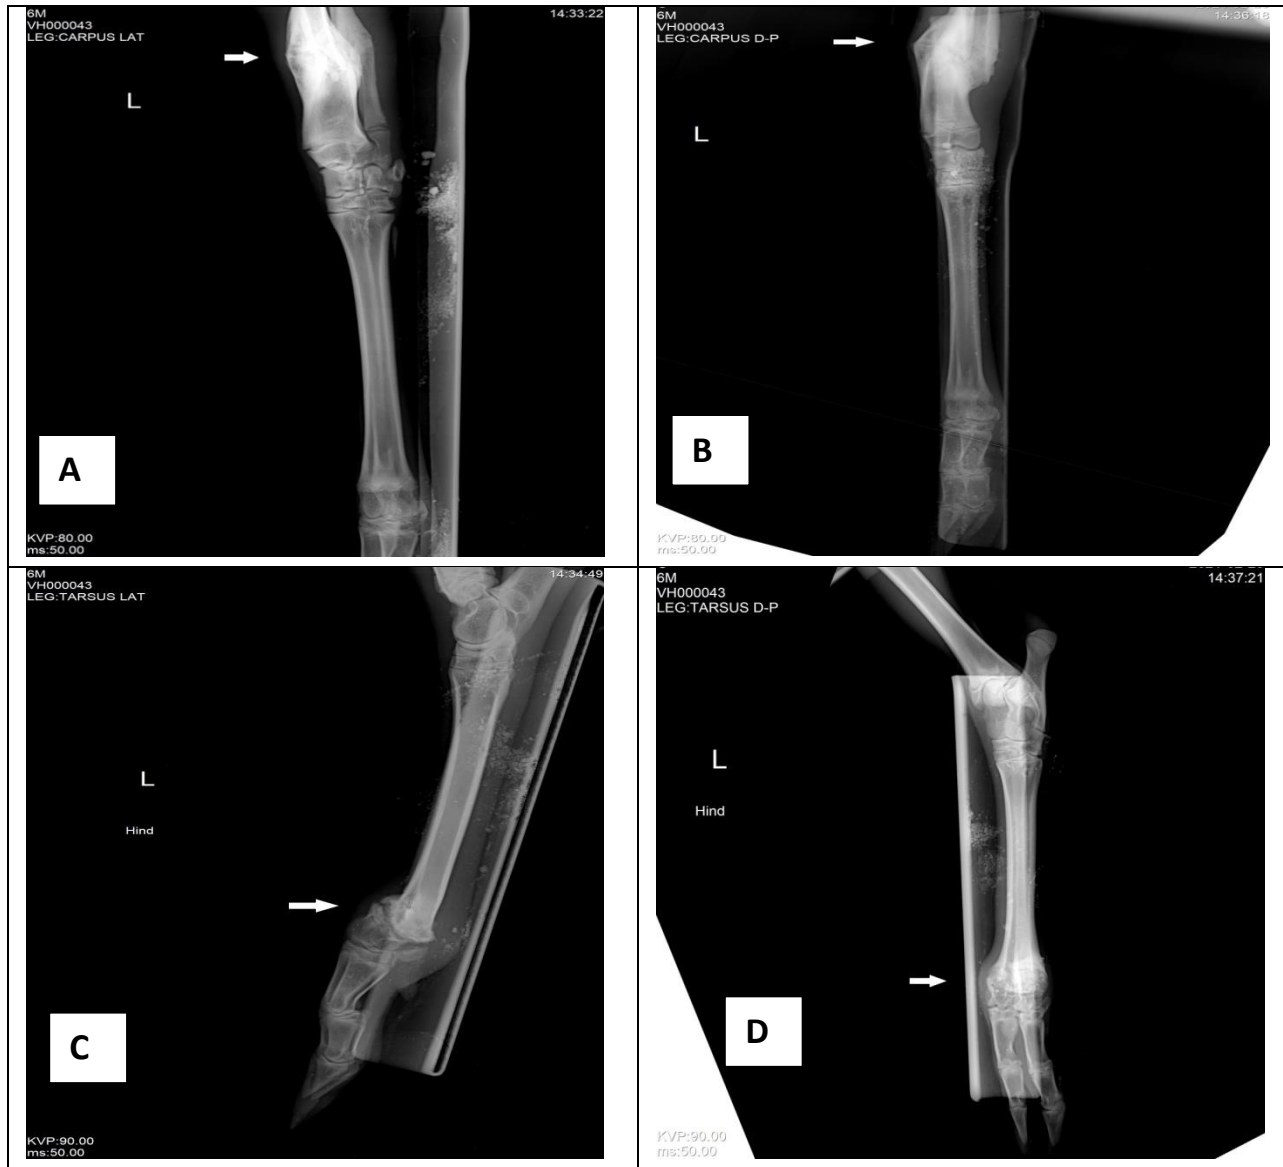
(A, B, C, and D). On radiography, comminuted fracture of the left radius-ulna and compound complete distal physeal fracture of the left metatarsus was confirmed.
